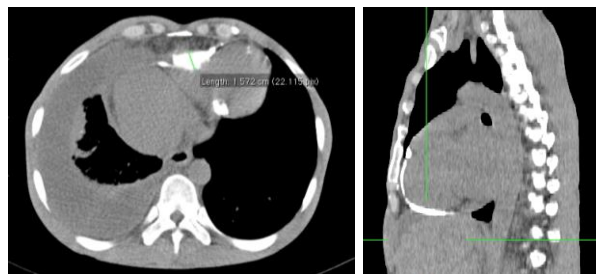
Preoperative CT scan axial view showing pericardial plate
